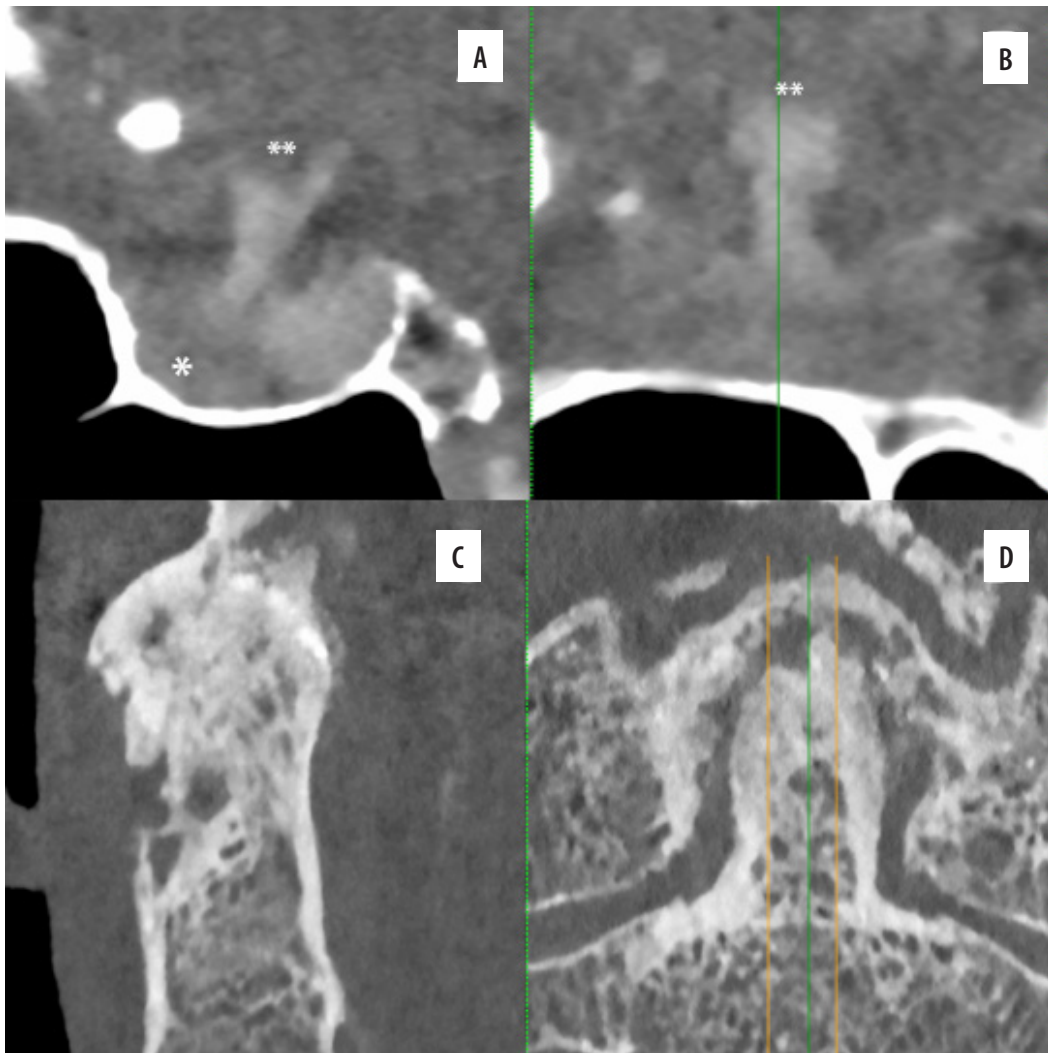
Photon-counting computed tomography (PCCT) examples of neuro applications. The figure shows the hypothalamus (), the hypophyseal pedicle, and the hypophysis (*; anterior hypophysis) in sagittal (A) and coronal (B) planes; in C and D a sagittal and coronal view of high-resolution of the epistropheus tooth with severe degenerative alterations. The scan was performed on a commercial whole-body dual-source photon-counting CT scanner (Naeotom Alpha, Siemens, Germany) with 0.2 mm slice thickness, 0.1 mm reconstruction increment, and FOV 140 mm. The images are displayed with a resolution matrix of 1024×1024 pixels on the source axial reconstructions with a kernel filtering of Bv60-80 (vascular kernel medium-sharp) and with the maximum intensity of quantum iterative reconstruction (QIR 4). The actual displayed resolution is 0.1 mm (100 microns)
